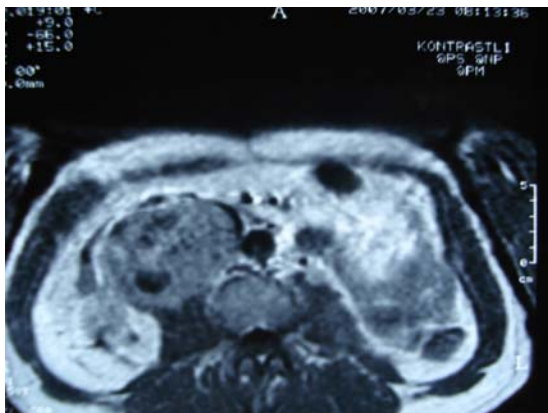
MRI scan shows a mass arising in the right retroperitoneum before second operation.
